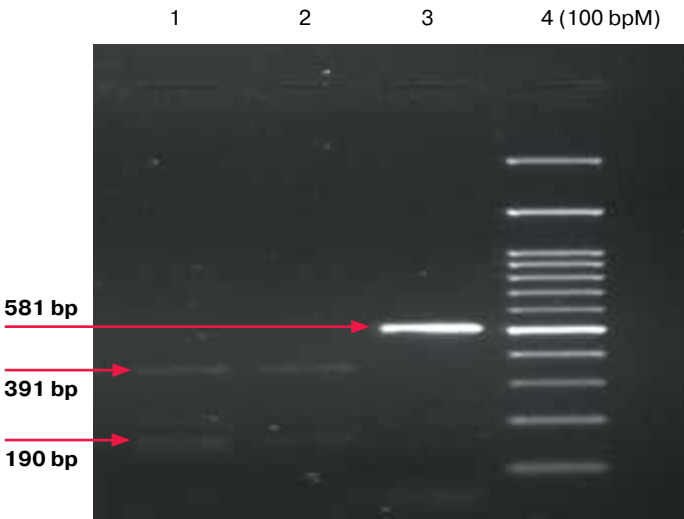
PCR product restriction enzyme analysis of PAX6 rs667773 single nucleotide polymorphism using BccI restriction enzyme. Digested samples were analysed by horizontal electrophoresis on a 3% agarose gel. Lane 1 and 2 resulted in heterozygote condition with CT genotype. Lane 3 resulted in an undigested 581bp fragment of genotype CC. Lane 4 is a 100bp DNA ladder
